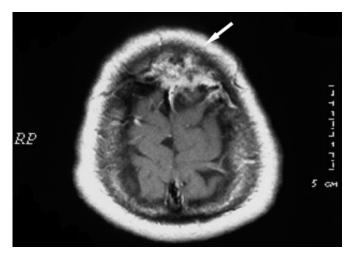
Cavernous hemangioma of the skull. Axial MRI in T1 sequence showing a large expansive and destructive hyperintense lesion within diploic suture and tabula interna of the left frontal bone (white arrow).
